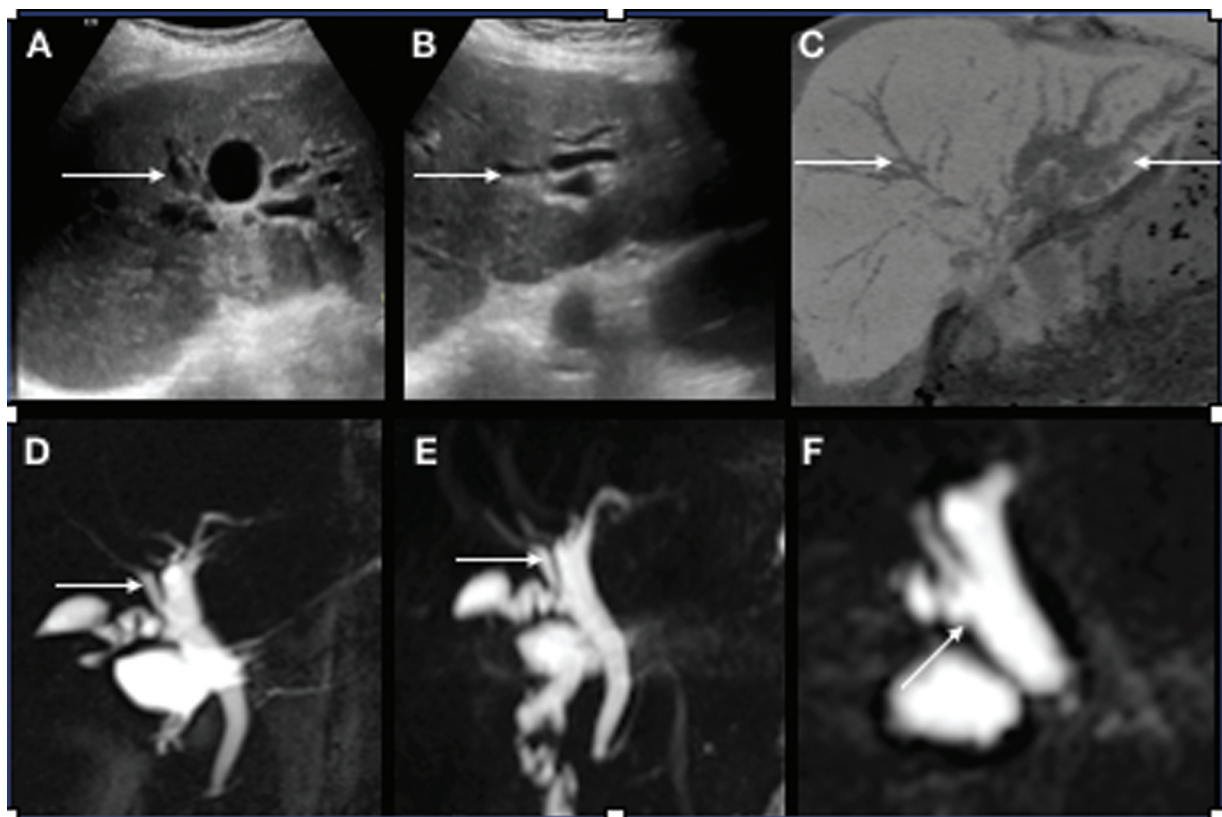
A 49-year-old male with jaundice. Ultrasonography (USG) images showing linear hypoechoic tubular structures (arrows) converging toward the hilum in the right (A) and left (B) lobes—dilated intrahepatic biliary radicles (IHBRs). (C) Minimum intensity projection (MinIP) computed tomography (CT) images clearly showing asymmetrically dilated IHBRs (arrows). Thick (D) and thin (E, F) slab magnetic resonance cholangiopancreatography (MRCP) showing aberrant IHBR drainage (arrows). Right posterior duct is clearly seen to drain into the cystic duct insertion on the thin three-dimensional (3D) MRCP sequence. Ultrasound cases and figures : Courtesy of Dr. Deeksha Rastogi, Department of Ultrasound, Sir Ganga Ram Hospital, Delhi, India.
